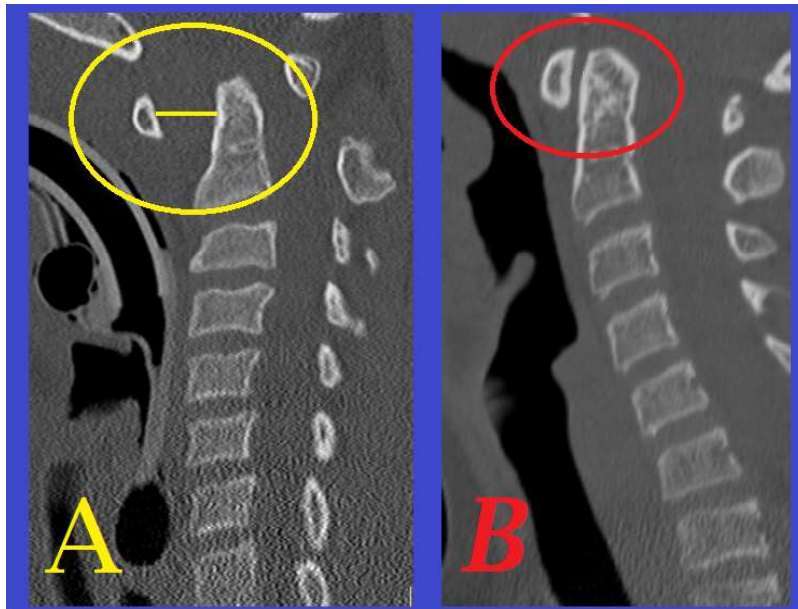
Mid-sagittal slice of a cervical spine CT scan. The image on the left (A) is of a 14-year-old boy with Down syndrome who was experiencing myelopathic symptoms due to atlantoaxial instability. The atlanto-dens interval, indicated by the yellow line, is ~13mm. The image on the right (B) is of a normal C-spine with a normal atlanto-dens interval for comparison.
